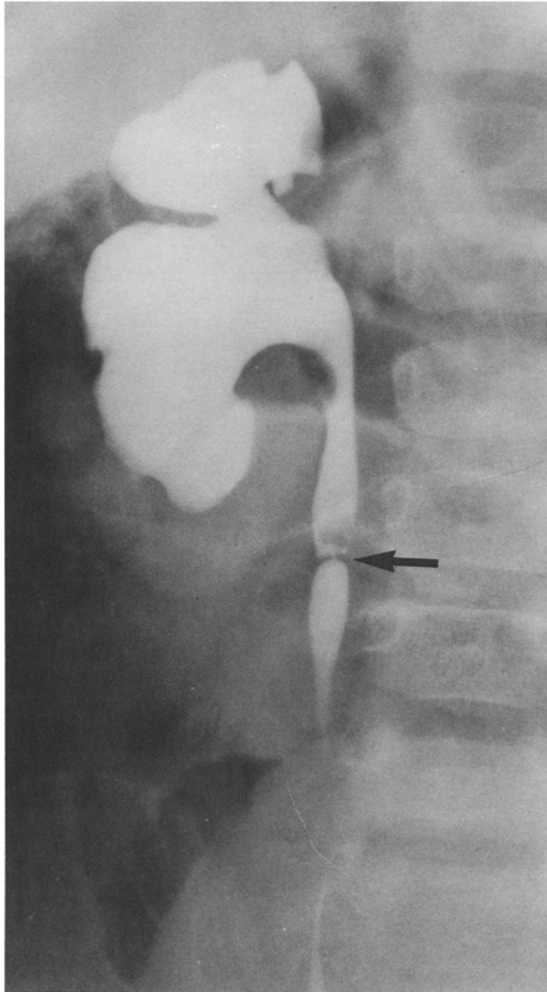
Case 2. Left retrograde ureteropyelogram demonstrating midureteral stricture (*arrow*). (Reproduced with permission from Young DW, Lebowitz RL: Congenital abnormalities of the ureter. *Semin Roentgenol* 21:172, 1986.)
